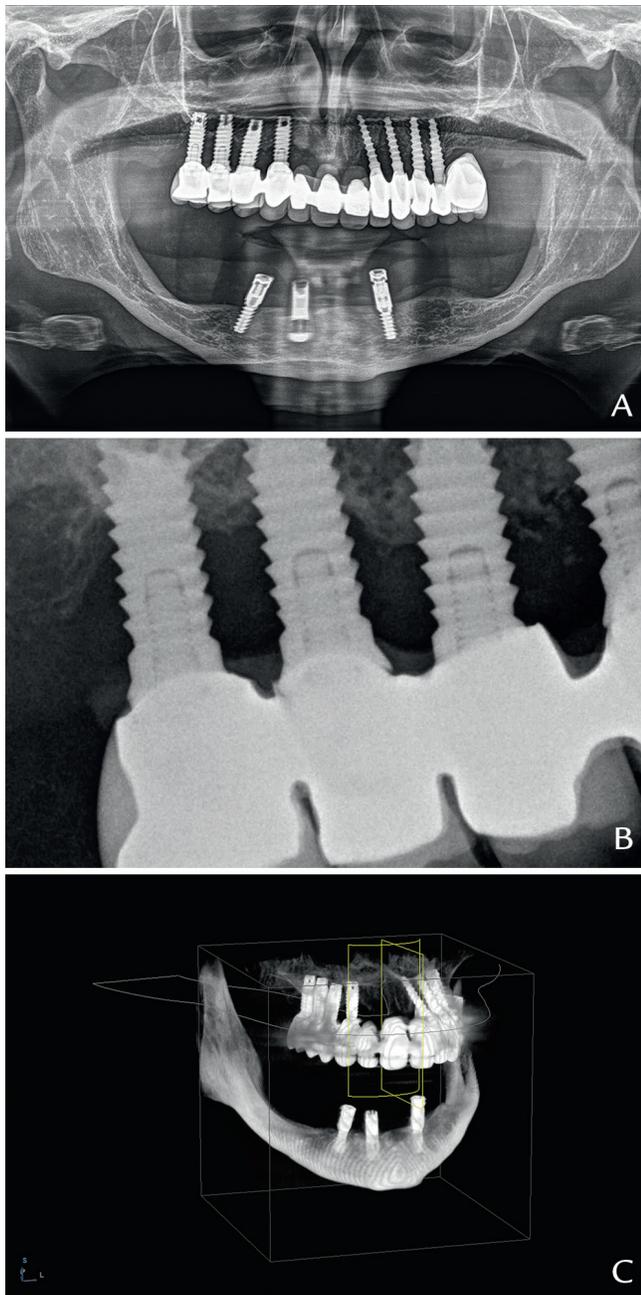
Pretreatment radiographs. A, Panoramic radiograph. B, Periapical radiograph of maxillary right implants. C, Cone beam computed tomograph.
